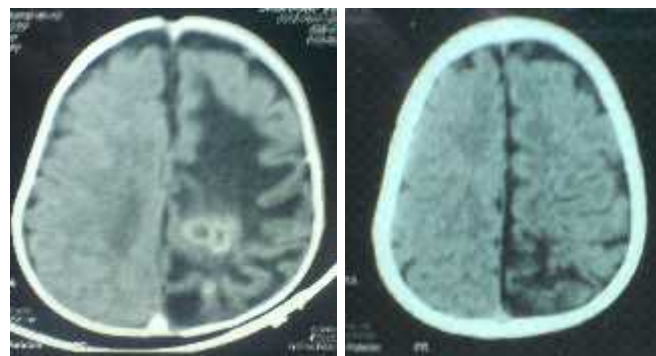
Pre-operative and post-operative CT images of brain
